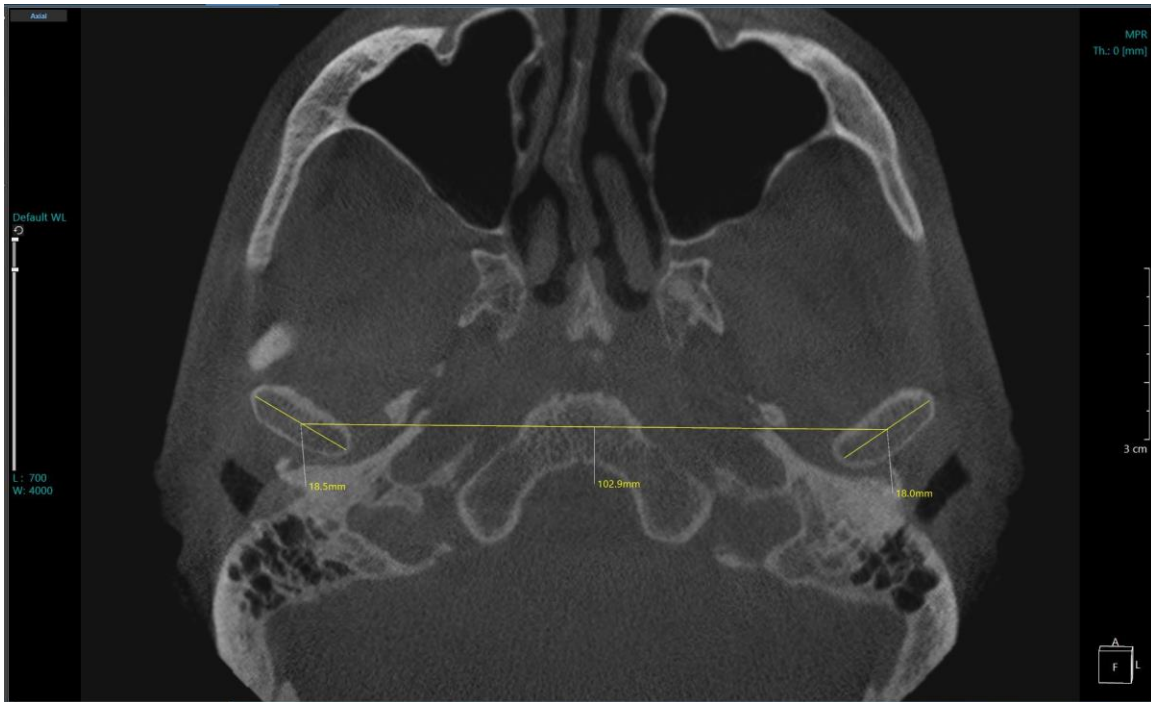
Axial CBCT view showing ICD from center of rotation of condyles. Xelis software automatically determines the midpoint of each condyle measurements. From the same midpoint of the right and left condyle, the digital ruler was selected once again and the ICD measurement was determined.
